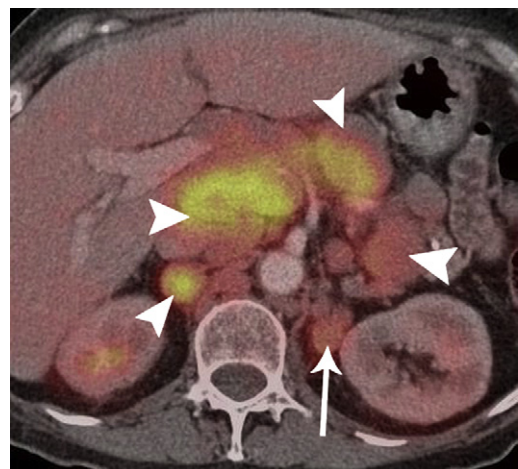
PET CT of lymphoma. Overlaid PET/CT image demonstrating a left adrenal mass (arrow) and multiple upper-abdominal lymph nodes (arrowheads), all showing increased FDG activity resulting from involvement with lymphoma.
